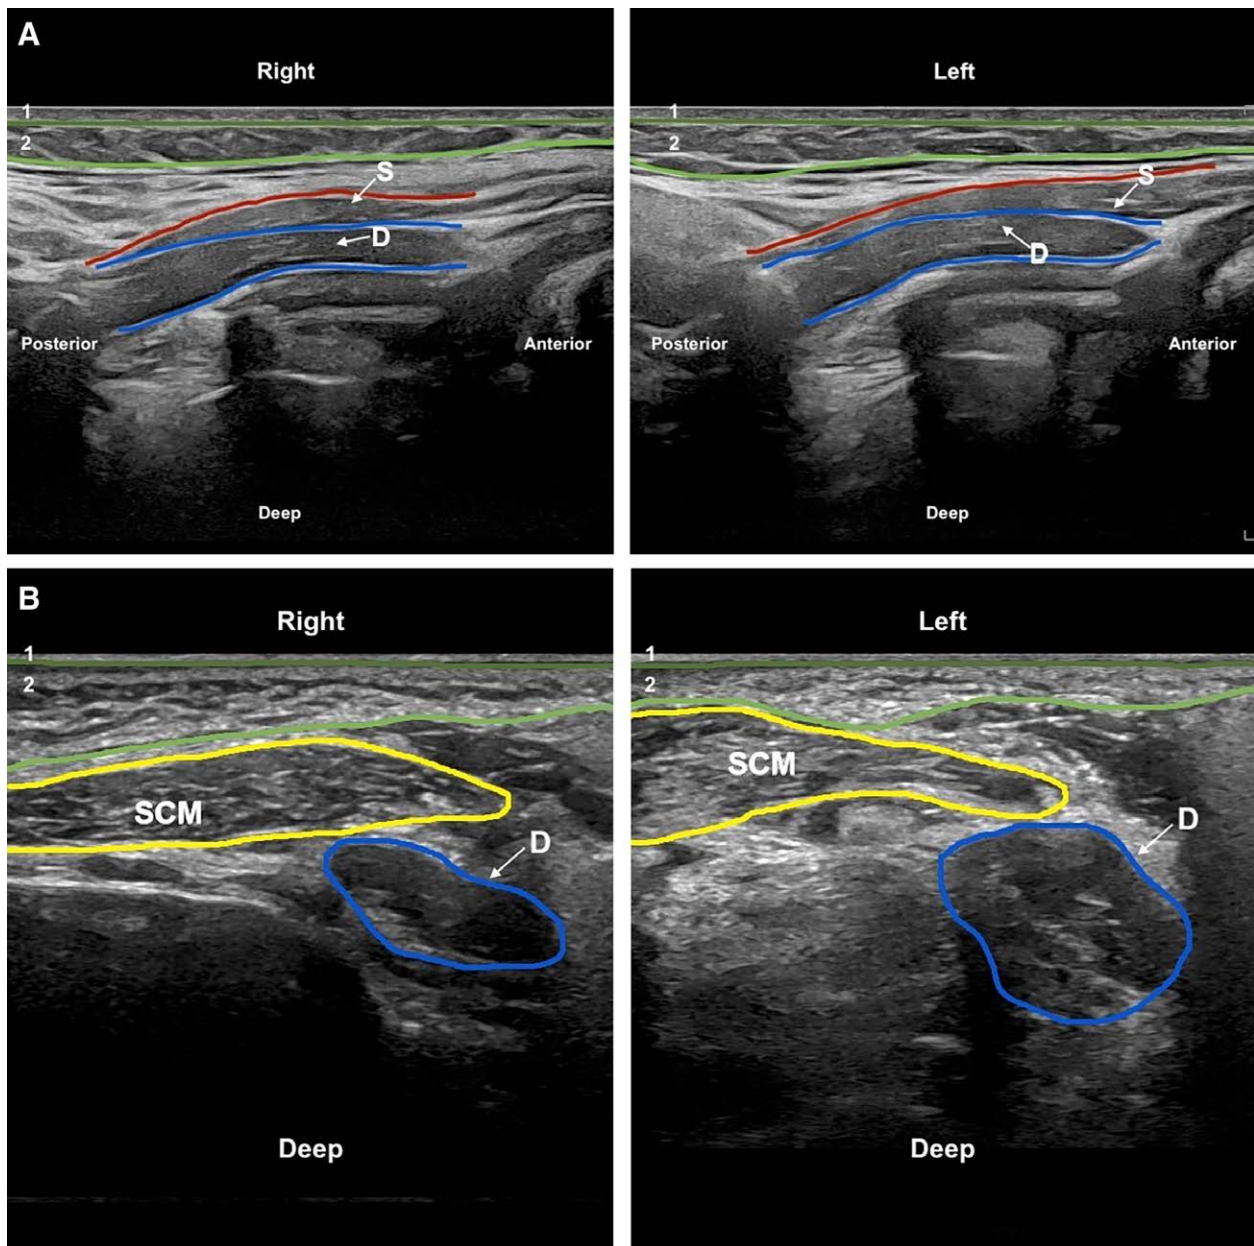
Neck ultrasound. A, Ultrasound image in a longitudinal view demonstrating the hypertrophy of the posterior belly of the digastric muscle (D) on the left side compared with the unaffected muscle on the right side. The skin (1) and the subcutaneous tissue (2) are marked in green, the stylohyoid muscle is indicated in red (S). B, Ultrasound images in a transverse view demonstrate the hypertrophy of the posterior belly of the digastric (D) on the left side clearly compared with the unaffected muscle on the right side. SCM, sternocleidomastoid muscle.
